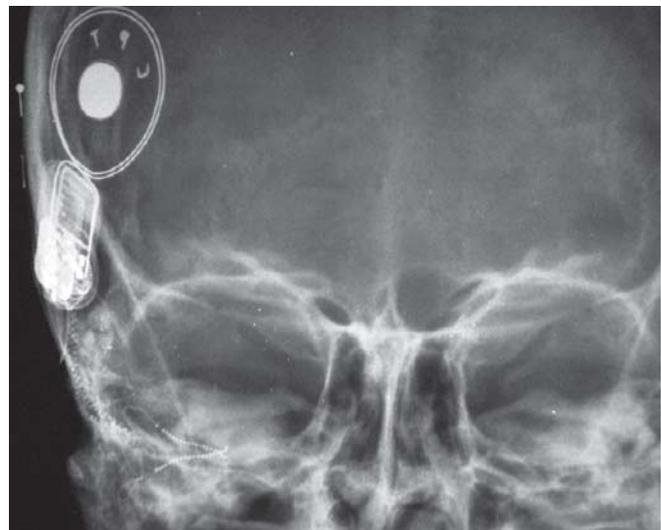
Postoperative X-ray in a patient with split array for ossified cochlea
